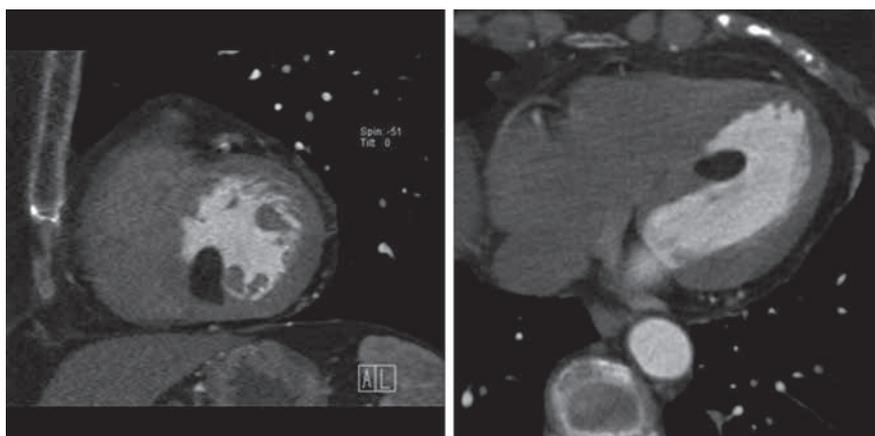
Short-axis (left) and transverse (right) CT image of a cardiac lipoma, arising from the inferobasal interventricular septum.
